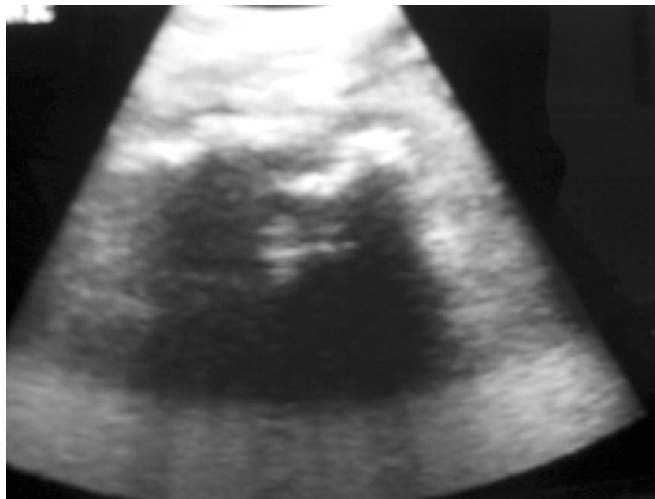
Ultrasonography of the abdomen showing complex mass with hyper and hypo-echoic areas in the lower abdomen
